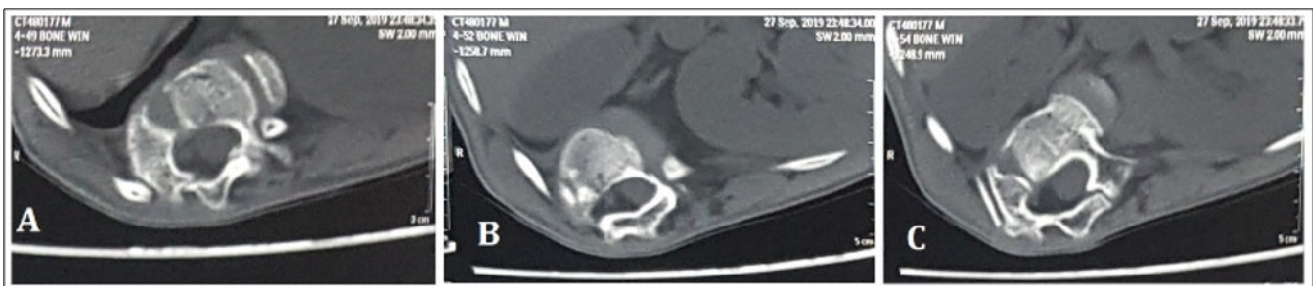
Preoperative serial CT scans (axial view) at D11 (A), D12 (B) and L1 (C) vertebral levels showing rotational deformity of vertebrae.
